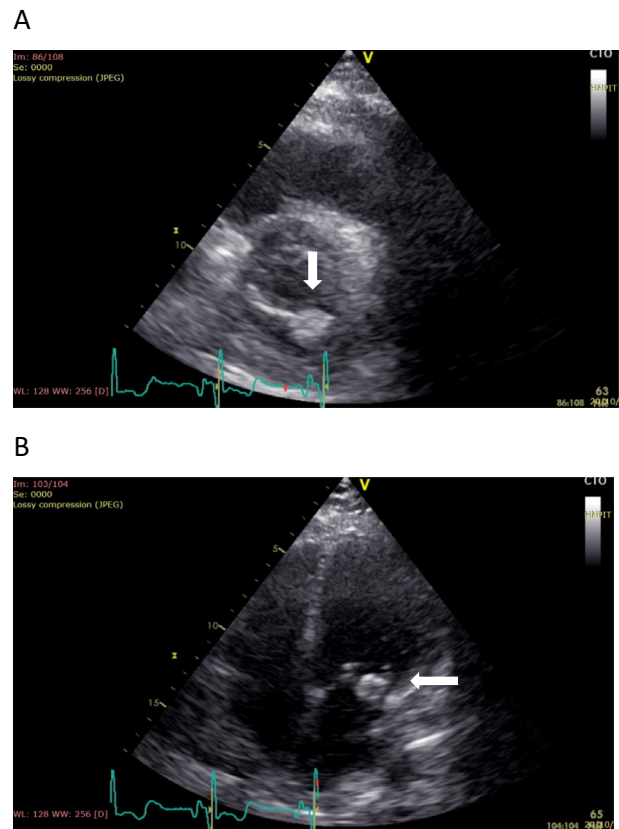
Transthoracic two-dimensional visualization of the mass. (A) Parasternal short axis view and (B) apical four-chamber view.
